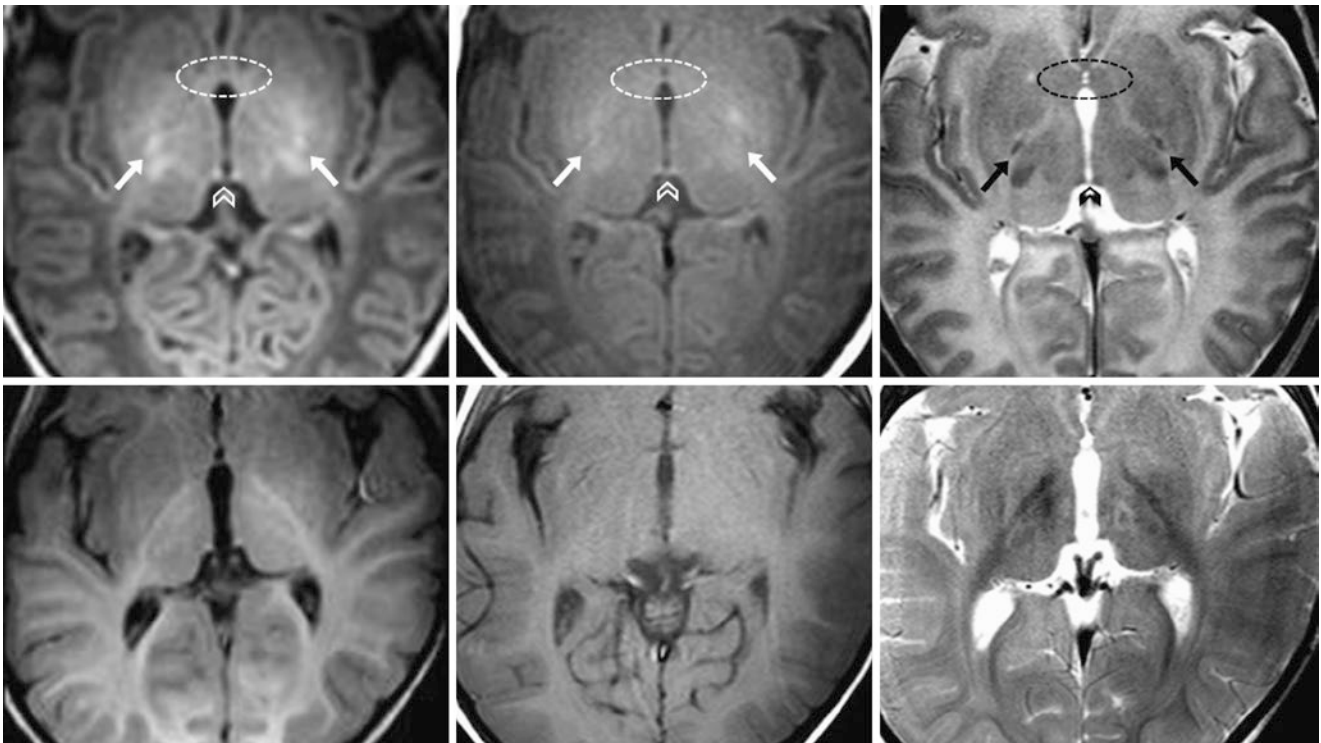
An 11-day-old term neonate had a normal 3T MRI with GE T1WI (top left), SE T1WI (top middle), and SE T2WI (top right). The PLIC (arrows) and HC (chevrons) both appear myelinated on each sequence. Note that the anterior commissure does not (dotted ovals). A follow-up MRI at 1 year demonstrated normal myelination on corresponding GE T1WI (bottom left), SE T1WI (bottom middle), and SE T2WI (bottom right), although there was some motion on the examination
